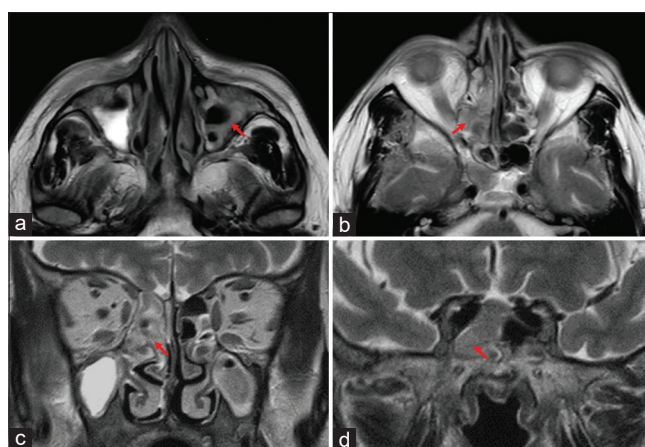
Sinus magnetic resonance imaging. Axial (a and b) and coronal (c and d) fast spin echo T2-weighted images show low signal effusion in the left maxillary sinus, at the level of ethmoidal air cells and sphenoid sinus, predominantly on the right (arrows).
